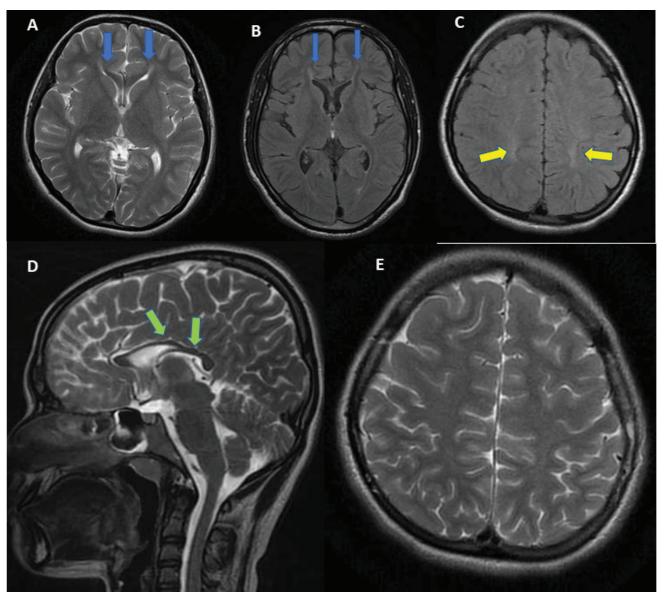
Axial T2 weighted (A, E), axial FLAIR (B,C) and sagittal T2 weighted MR images of brain (A) and (B), High signal intensity can be seen along the ends of the frontal horn of bilateral lateral ventricles involving the forceps minor of the genu of corpus callosum similar to the ears of the lynx. [blue arrows] There is hyperintense signal in bilateral centrum semiovale [yellow arrows in (C)] with thin corpus callosum [green arrows in (D) and widened sulci in bilateral cerebral hemisphere (E) which represents, cerebral atrophy
